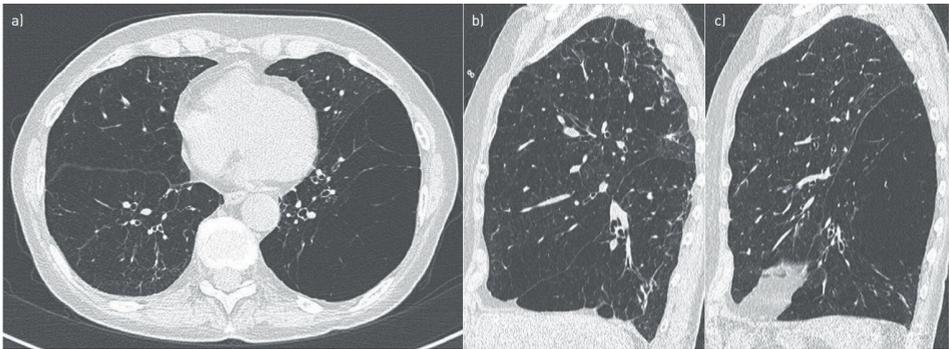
HRCT scan showing severe emphysema predominantly in the lower lobes and moderate central and peripheral bronchopathy with mucus plugging. Both major fissures appear to be complete.
